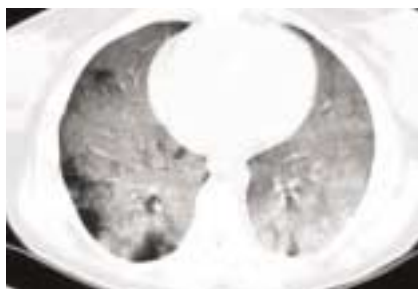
A pulmonary view of the chest CT depicts diffuse bilateral alveolar opacities.
